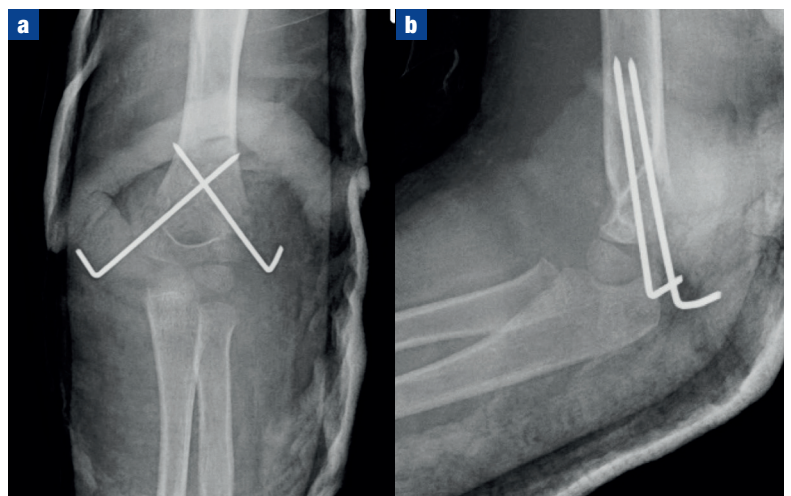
a. Anterior-posterior and (b) lateral radiographs of the crossed wire fixation technique.
